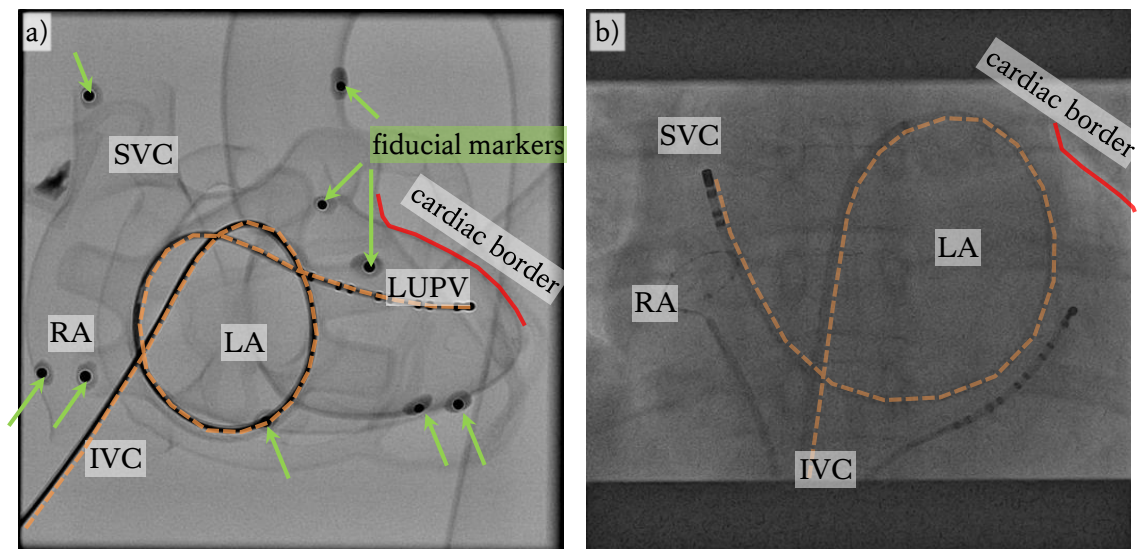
Posterior-anterior X-ray image of a a) plastic heart and b) clinical patient's heart with loop (*orange curve, dashed*) formed by inserting a catheter through the inferior vena cava (IVC) passing through the right atrium (RA) and inter-atrial septum and into the left atrium (LA) where it follows the chamber's inner wall with the loop exiting via a) the left upper pulmonary vein (LUPV) and in b) the superior vena cava (SVC). Upper cardiac border (*red curve, solid*) is highlighted and in a) radio-opaque fiducial markers used to obtain a gold-standard registration are identified (*tip of green arrows*).
